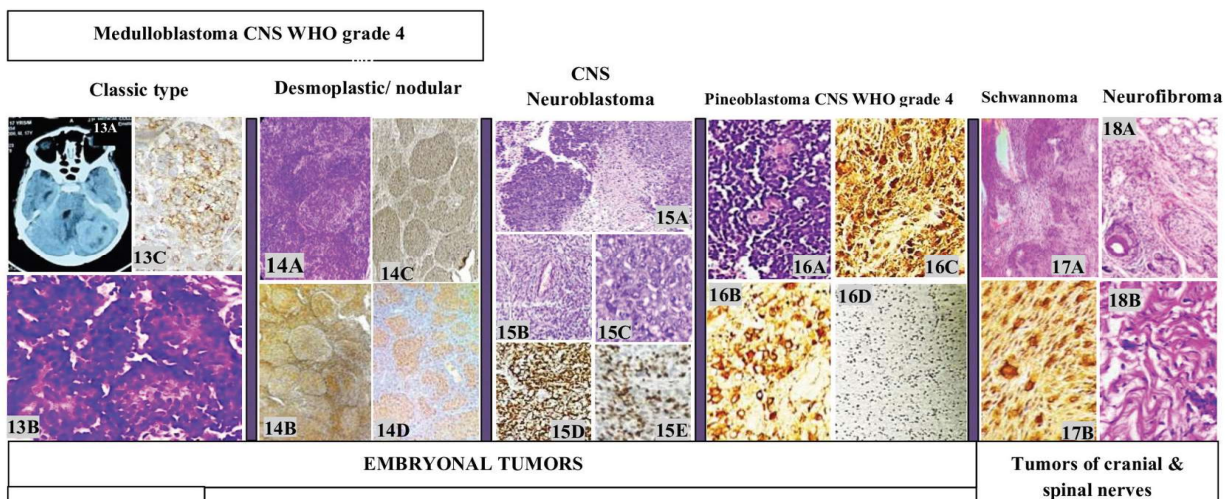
Fig. 13A MRI showed a hyperdense midline posterior fossa mass arising from the cerebellar vermis, compressing the 4th ventricle and causing obstructive hydrocephalus, with surrounding edema and heterogeneoenhancement; Fig. 13B showed small round blue cells with hyperchromatic nuclei and a high N:C ratio and Homer Wright rosettes with focal synaptophysin positivity (Fig. 13C). Figure 14A showed pale nodular areas with neuronal differentiation surrounded by densely packed hyperchromatic cells with reticulin-positive internodular regions (Fig. 14B, IHC-10X), NSE +ve pale nodules (Fig. 14C, IHC-10X) and synaptophysin-positive nodules and negative internodular areas (Fig.
